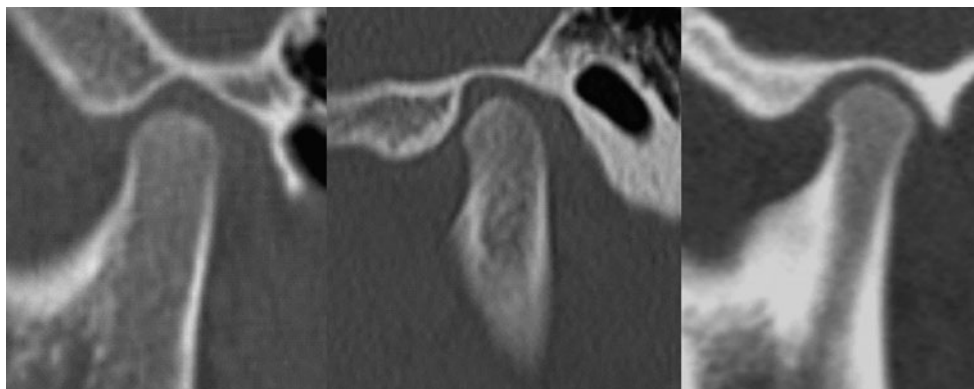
Reformatted sagittal computed tomography images demonstrating the three different types of condylar shape as described in our study: type I (*left*) showing a smooth, round shape, which is most frequently seen in children aged 0–5 years; type II (*centre*)
